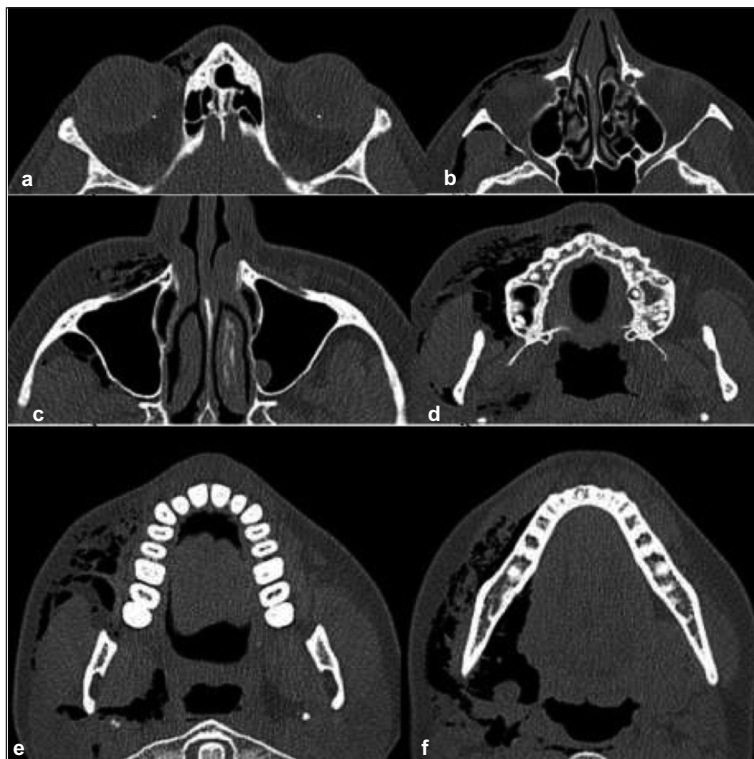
Axial Computed Tomography (CT) scans of the head and maxillofacial region showing subcutaneous emphysema (SE) extending to oropharyngeal and hypopharyngeal spaces on the right side.
